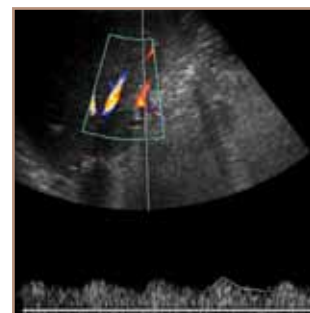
Power Doppler ultrasound is used to detect slow flow in small vessels; this image of the testis shows the presence of venous and arterial blood flow and therefore excludes the possibility of testicular torsion.
